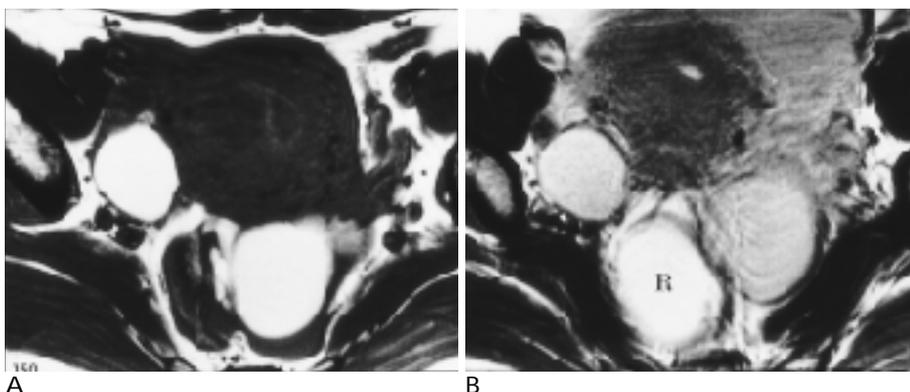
Bilateral ovarian endometrioma in a 29-year-old woman. SE T1-weighted axial image without Magnevist Enteral (A) shows bilateral ovarian masses, with homogeneous high signal intensity, SE T1-weighted axial image with Magnevist Enteral (B) shows decreased image quality due to artifact and the signal intensity of the masses are similar to the contrast-filled rectum (R).
